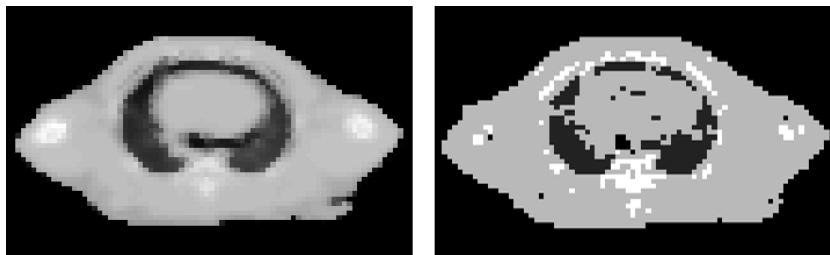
Axial slice of a CT based attenuation map (left) and corresponding MR based attenuation map (right) derived from a T₁ weighted image.
